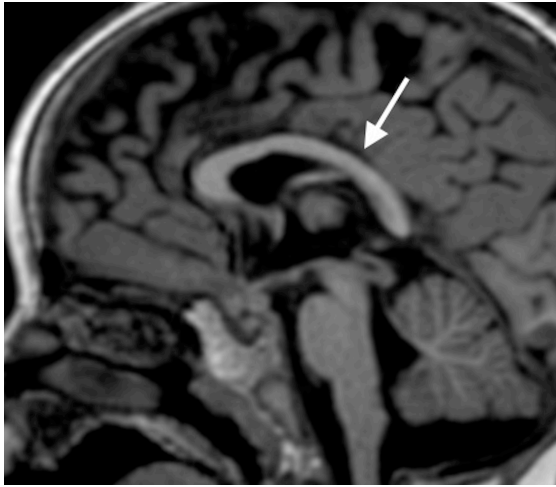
Midline T1 sagittal MRI scan shows the fornix is seen inserting into zone 3 (arrow) in a 4-year-old girl presenting with seizures and a normal MRI scan
